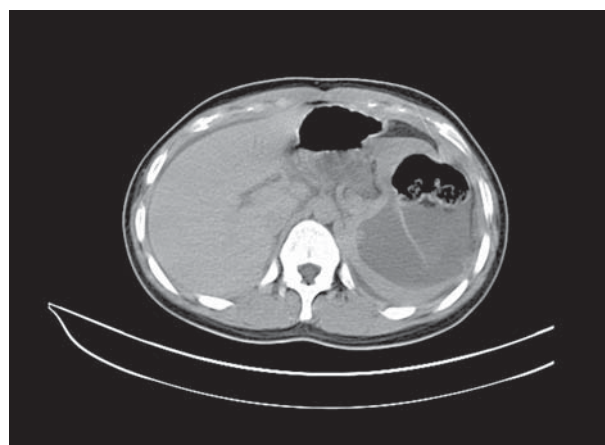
CT scan showed a ruptured splenic cyst with hematoma.
